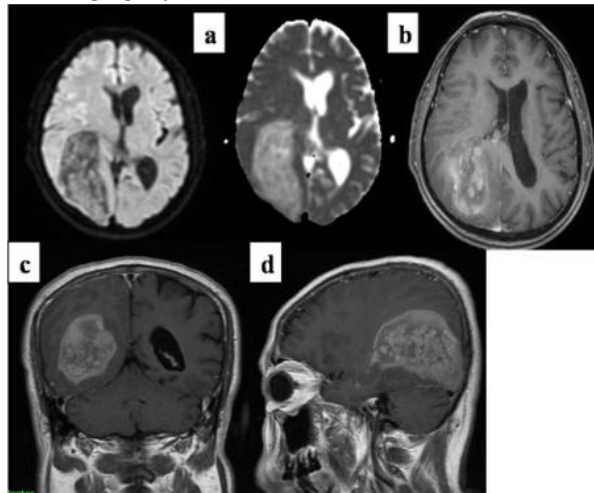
(a) DWI with ADC reveals mild restriction. (b) axial, (c) cor, (d) sag post contrast images demonstrating enhancing clustered nodular lesions appearing as a solitary heterogeneous mass of approx 77 x 41 x 54 mm with smooth and fairly well defined margins, centered at trigone of right lateral ventricle inseparable from CP, extending upto cortex. Mass effect is seen.
